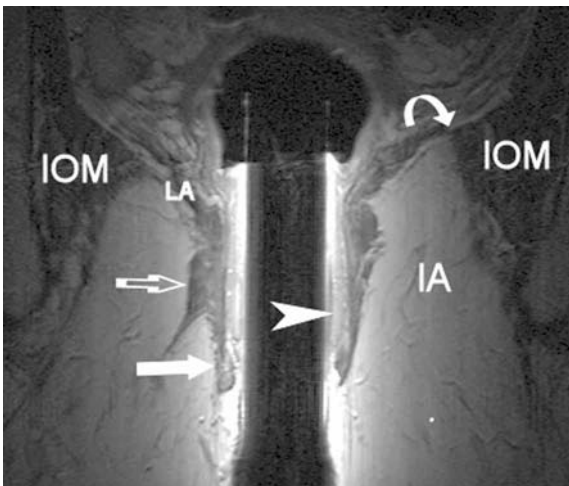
42. Endoanal coronal oblique T2-weighted turbo spin-echo in a woman. The internal anal sphincter (*arrowhead*) has a multilayered appearance. Longitudinal muscle (*thick curved arrow*) in intersphincteric space, external sphincter (*arrow*), puborectal (pubovisceral) muscle (*open arrow*), iliococcygeal part of the levator ani (*LA*)
